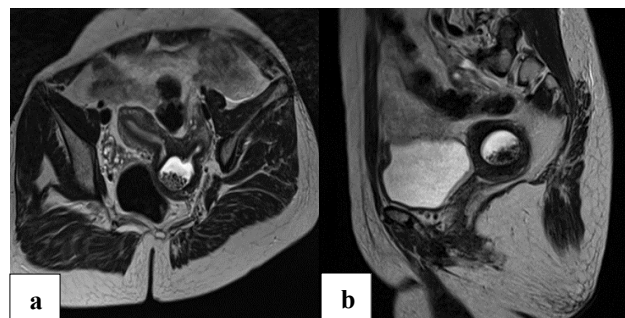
(a) Axial T2 MRI showing uterine didelphys with a deep fundal cleft and hematocolpos, and (b) sagittal T2 MRI demonstrating hyperintense hematocolpos in the left hemivagina.
